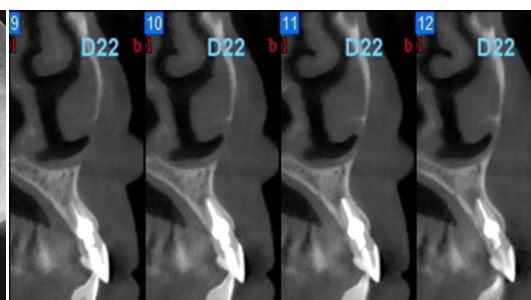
Decreased size of the periapical lesion in one-year follow-up CBCT (sagittal view).
